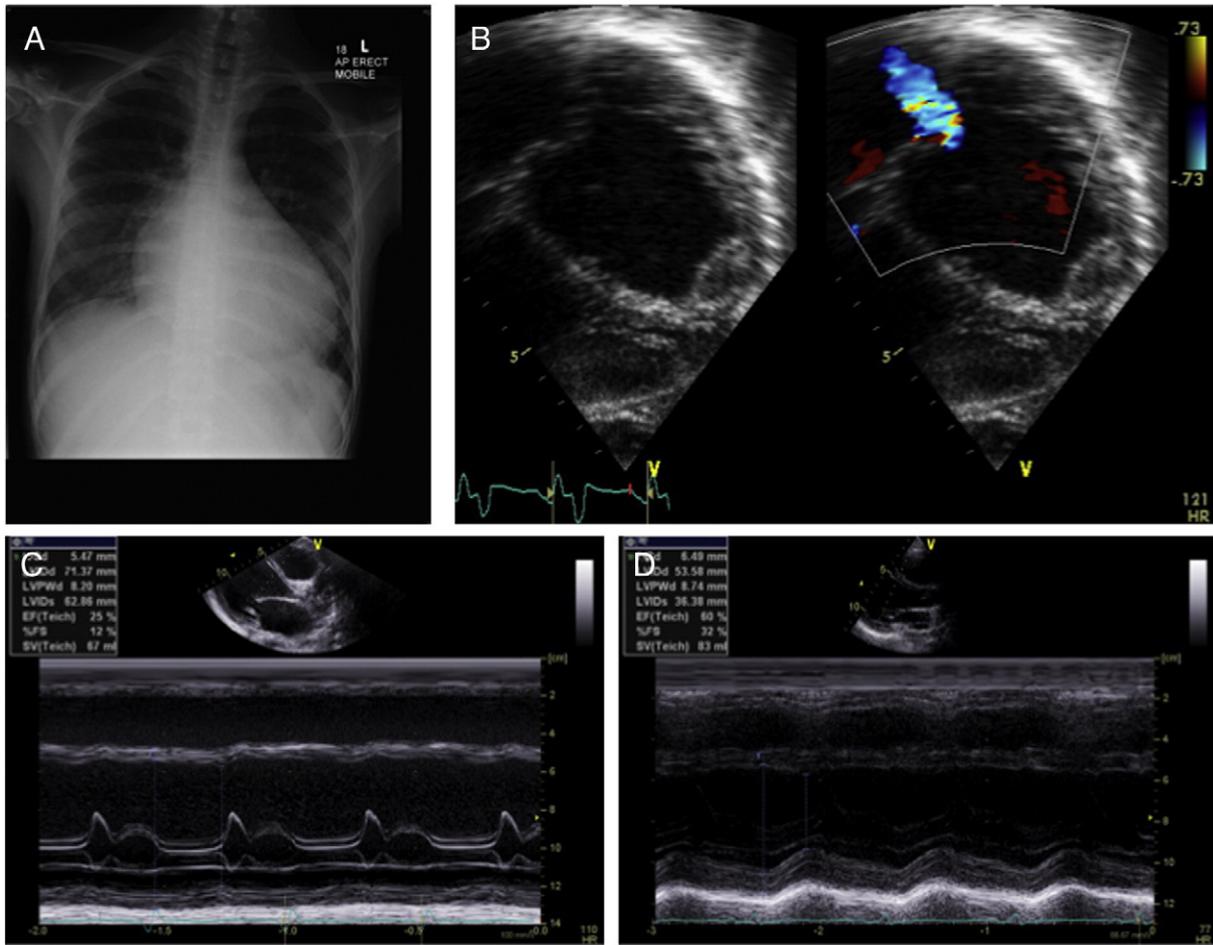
A: Chest X-ray at admission: cardiomegaly. B: Echocardiography mode 2D (left)/colour Doppler (right): Left ventricle dilation, mitral regurgitation and apical thrombus before Berlin Heart implantation. C: Echocardiography M-mode: At admission, shortening fraction 12%, diastolic left ventricle internal diameter 7.2 cm (Z score + 10.1). D: Echocardiography mode TM: At discharge, shortening fraction 32%, diastolic left ventricle internal diameter 5.3 cm (Z score + 3.2).
